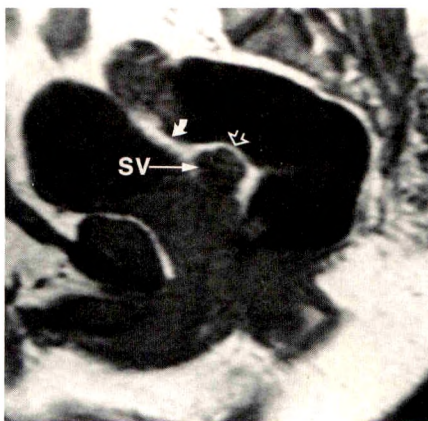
T1-weighted sagittal MR scan of pelvis shows mild extrinsic mass effect (open arrow) on air-filled rectosigmoid junction by enlarged seminal vesicle (SV). At surgery, prostatic carcinoma invaded seminal vesicle but not rectum. This sagittal MR scan is the correlate of the smooth extrinsic mass impression on the rectosigmoid junction seen on barium enema in Fig. 3. Note that peritoneal reflection has been lifted cranially and anteriorly (curved arrow) because of prostatic and seminal vesicular enlargement.
